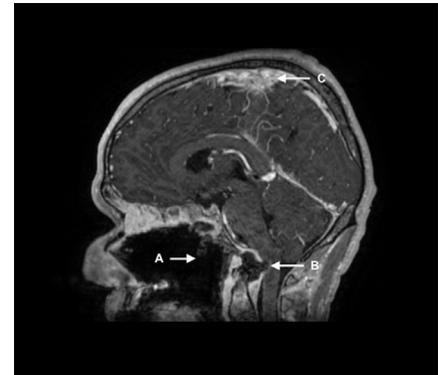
Sagittal contrast MRI showing a palatal defect marked (A) with soft tissue swelling and fluid collection compressing into the craniocervical junction causing myelopathy (B). An area of pachymeningitis is labelled (C).
